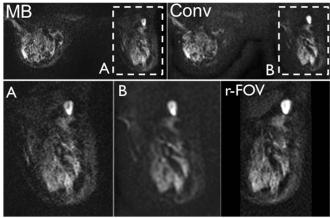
Comparison between MB, conventional (Conv) and r-FOV DWI (b= $600 s/mm^2$)
